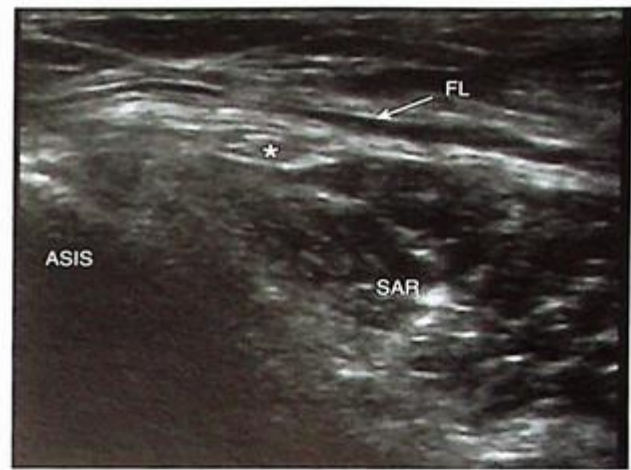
Ultrasound-guided LFCN block.
